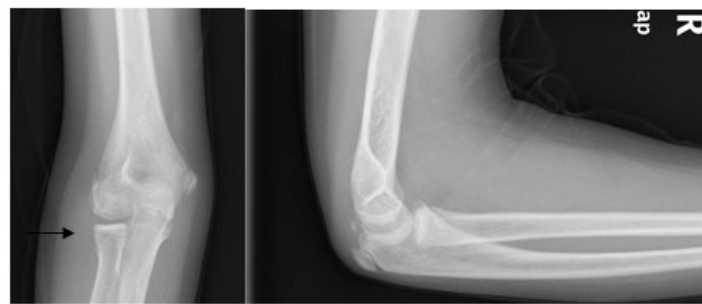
X-rays after 1 year of follow-up. The physal arrest of the radial head can be seen (arrow).
